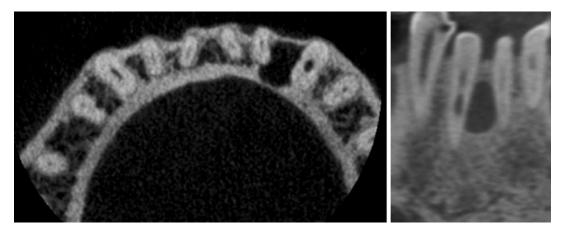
Lateral Periodontal Cyst. A: CBCT Axial slice reveals a unilocular hypodense lesion with well-defined borders at the lateral site of the roots without any
